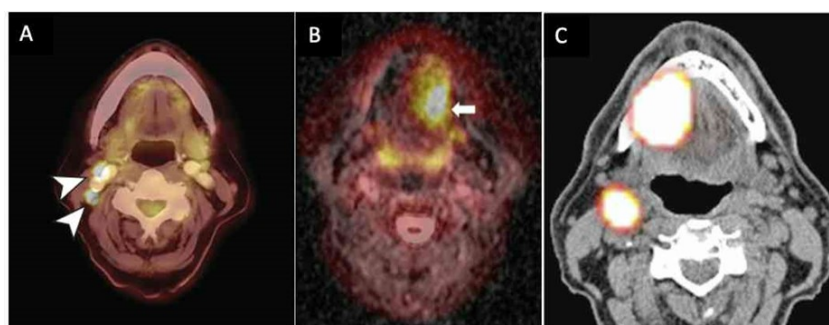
Representative image of tongue cancer on (A) PET-CT¹⁴, (B) PET/MRI³⁹, (C) SPECT-CT⁴⁰
